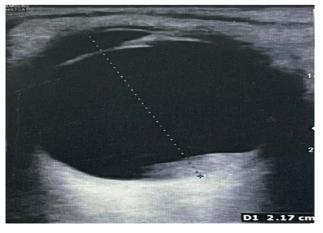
Vitreous in the form of a mass on B-mode ultrasound of the left eye.
